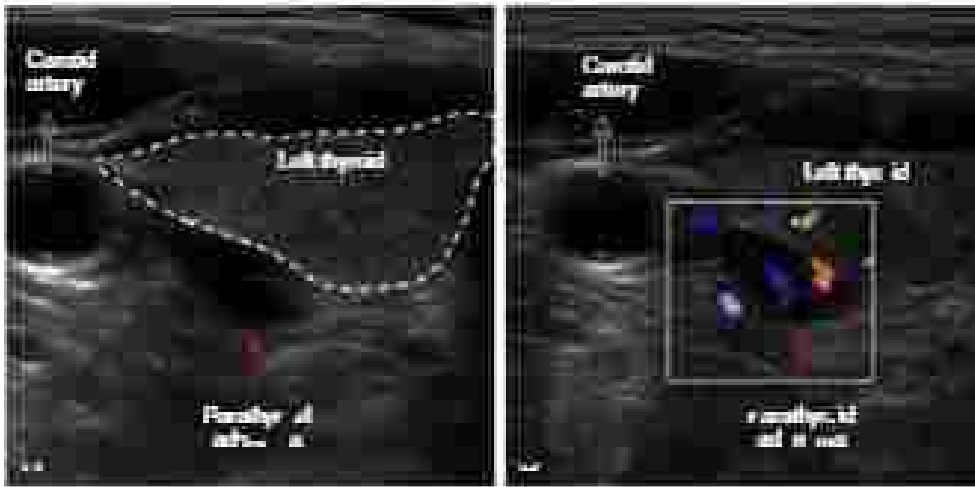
Doppler ultrasound image of the carotid artery and left thyroid gland. A red arrow points to a parathyroid adenoma. The color Doppler image shows a red arrow pointing to the parathyroid adenoma. The color Doppler image shows a red arrow pointing to the parathyroid adenoma.
